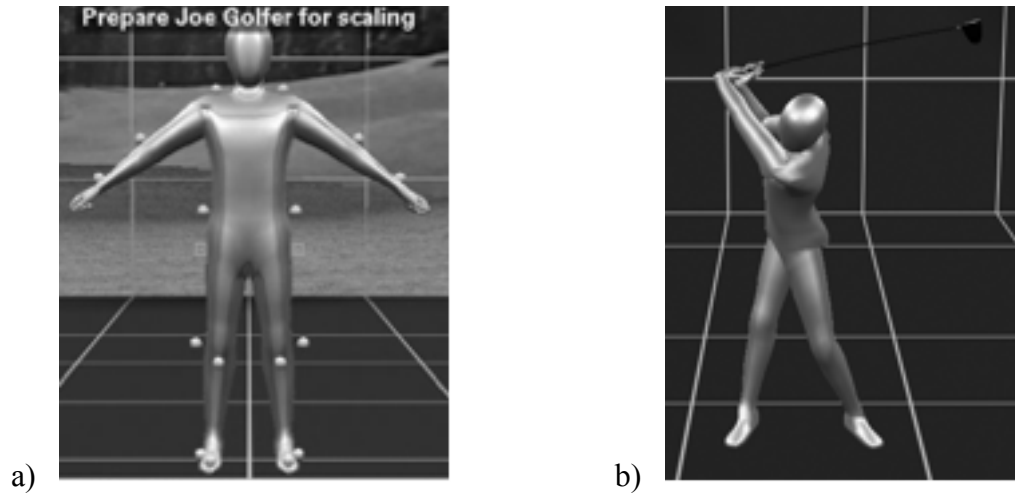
a)* Scaling the MRI kinematic model to markers on a subject. *b)* Animated golf motion from the MRI kinematic golf model.
